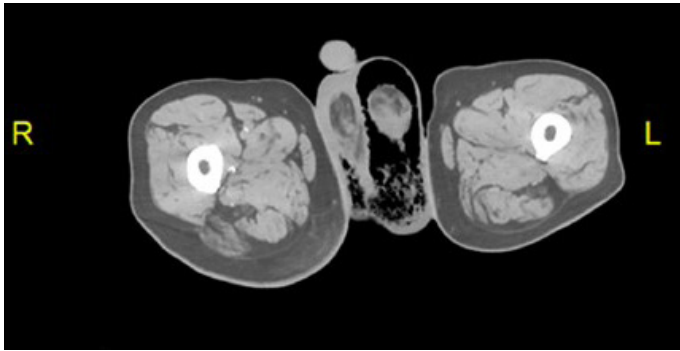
CT abdomen pelvis demonstrating Fournier's Gangrene with extensive air within the scrotal tissue.
